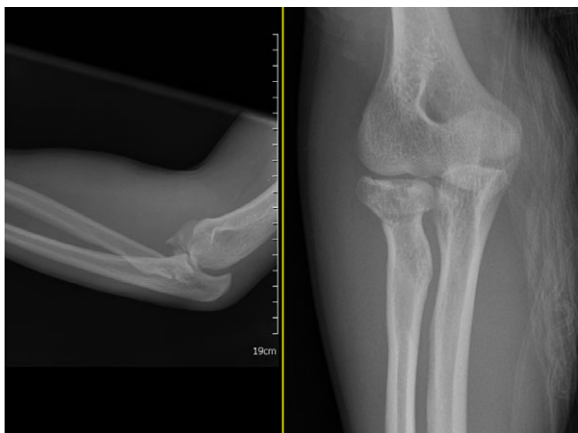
Lateral radiograph elbow
